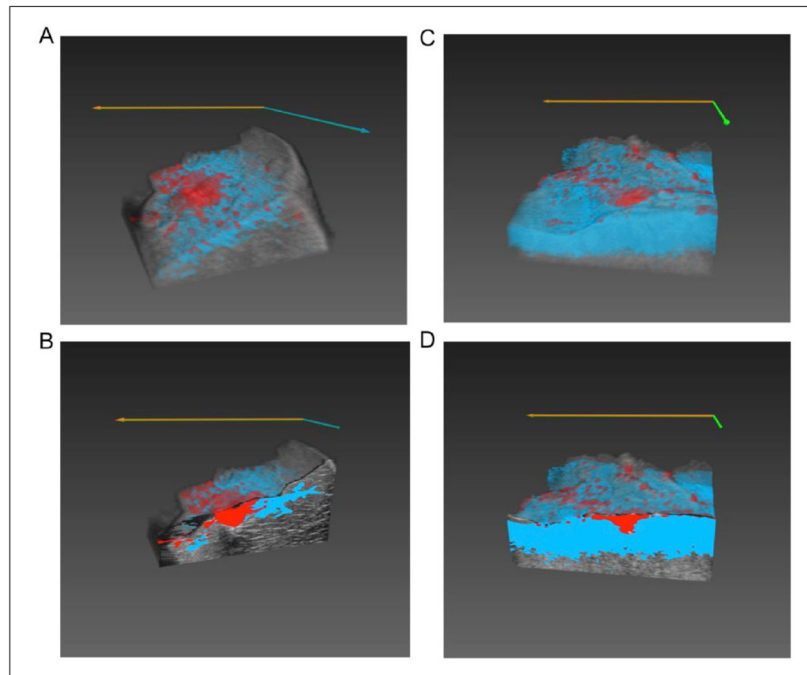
Renderings of 3D TCM volumes overlaid matching 3D US volumes: (A) full liver sample 3D volume rendering; and (B) cut-away view of 2D frame in the interior of the lesion of the same liver volume; (C) full cardiac sample 3D volume rendering; and (D) cut-away view of 2D frame in the interior of the lesion of same cardiac volume. TCM = tissue characterization map; US = ultrasound.
